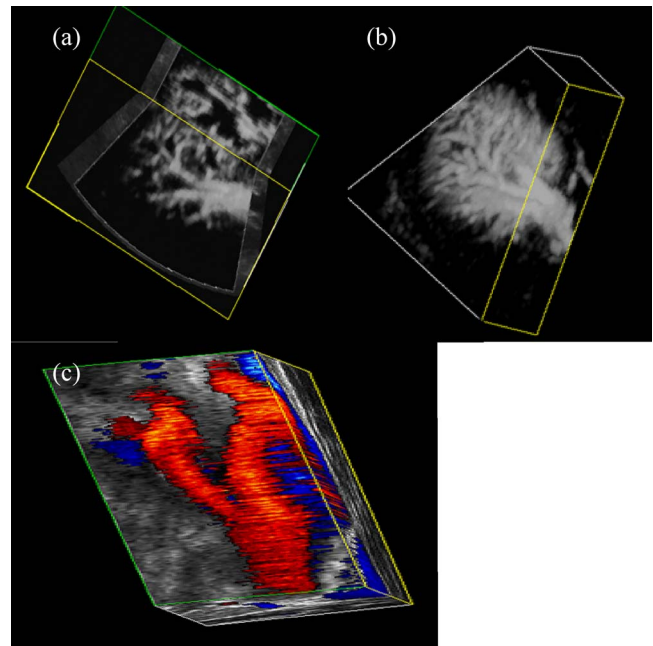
Three-dimensional ultrasound images obtained using a mechanical scanning mechanism and shown using a cube-view approach. (a) B-mode image of a kidney; (b) power Doppler image of a kidney; (c) Doppler image of the carotid arteries, showing reverse flow in the carotid sinus.
